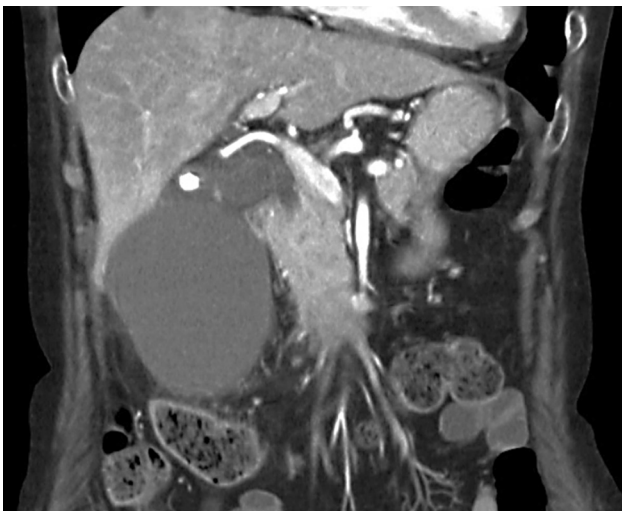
CT showed segmental adenomyomatosis and acute cholecystitis on the fundus segment of the gallbladder.
